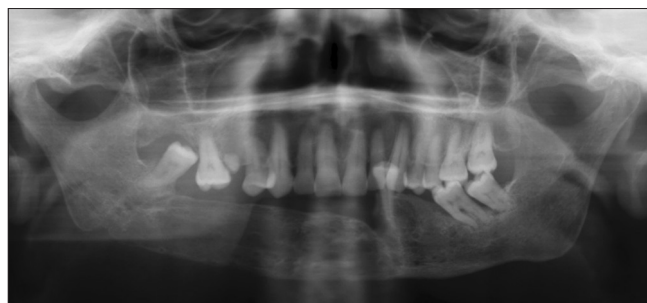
Radiographic control after distraction osteogenesis. Vertical augmentation of the bone is significant
